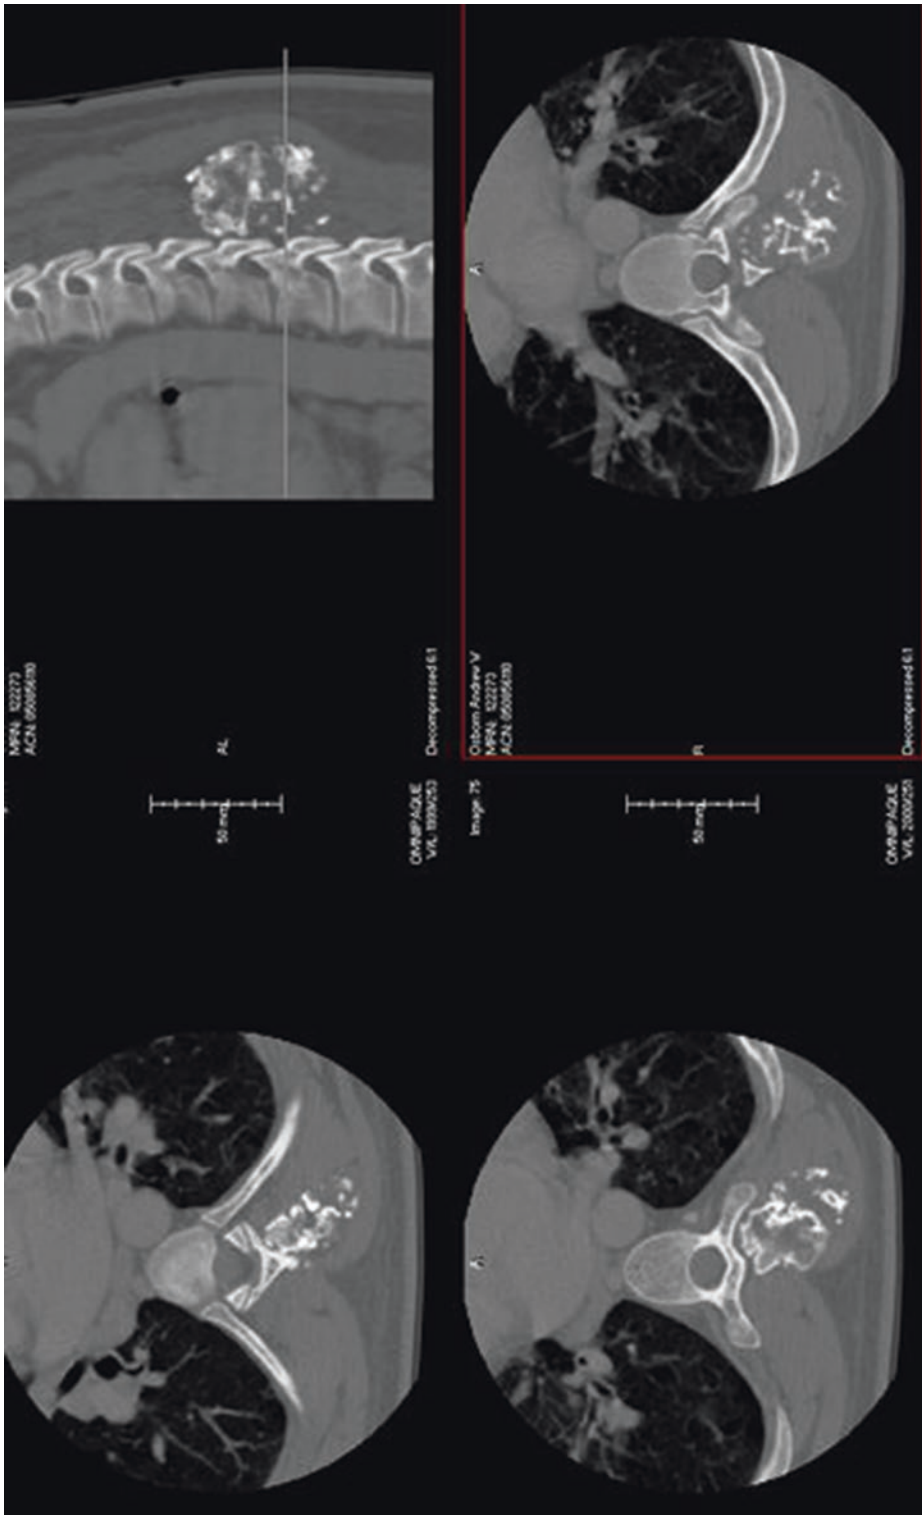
Case 2: CT images demonstrating largely calcified mass arising from the left T12 transverse process but extending over T11-L1. Note the well-demarcated tumor capsule consistent with Enneking Stage IB lesion
